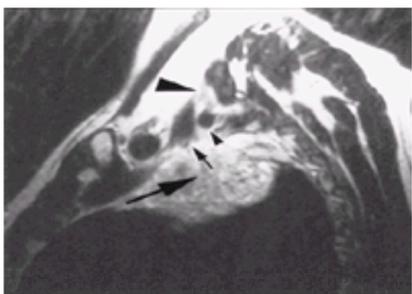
Pancoast's tumor. A 42-year-old man with mild cough. Posterior superior mediastinal mass was identified on plain radiograph. Sagittal T2 images demonstrate the pulmonary apex mass that abuts but does not surround the subclavian artery. At surgery, the mass was found to be a hemangioma. Magnetic resonance imaging is useful for evaluating the extent of chest wall tumors as well as brachial plexus and vascular invasion.
